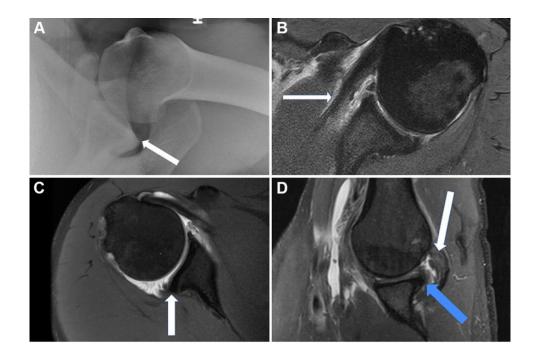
(A) An axillary lateral radiograph demonstrating posterior glenoid dysplasia (white arrow). (B) A short-tau inversion recovery (STIR) sequence axial MRI demonstrating perimuscular and peritendinous edema of the subscapularis (white arrow). (C) A T1-weighted fat-saturated axial MRI noting posterior glenoid dysplasia and posterior-superior labral tearing (white arrow). (D) A T1-weighted fat-saturated abduction-external rotation axial oblique MRI showing partial-thickness articular-sided posterior superior rotator cuff tearing (solid white arrow) and posterior superior labral pathology (blue arrow). MRI, magnetic resonance imaging; STIR, subscapularis muscle on short-tau inversion-recovery.
